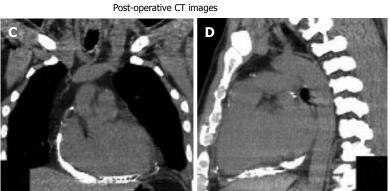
Computed tomography. Non-contrast computed tomography reconstructed images in coronal (A) and sagittal (B) planes show thick, calcified pericardium around the heart. A repeat CT following partial pericardiectomy in coronal (C) and sagittal (D) planes show residual calcified pericardium at right atrial and posterior surface of the heart. Calcified pericardium is absent along the antero-lateral surface of the heart. CT: Computed tomography.
